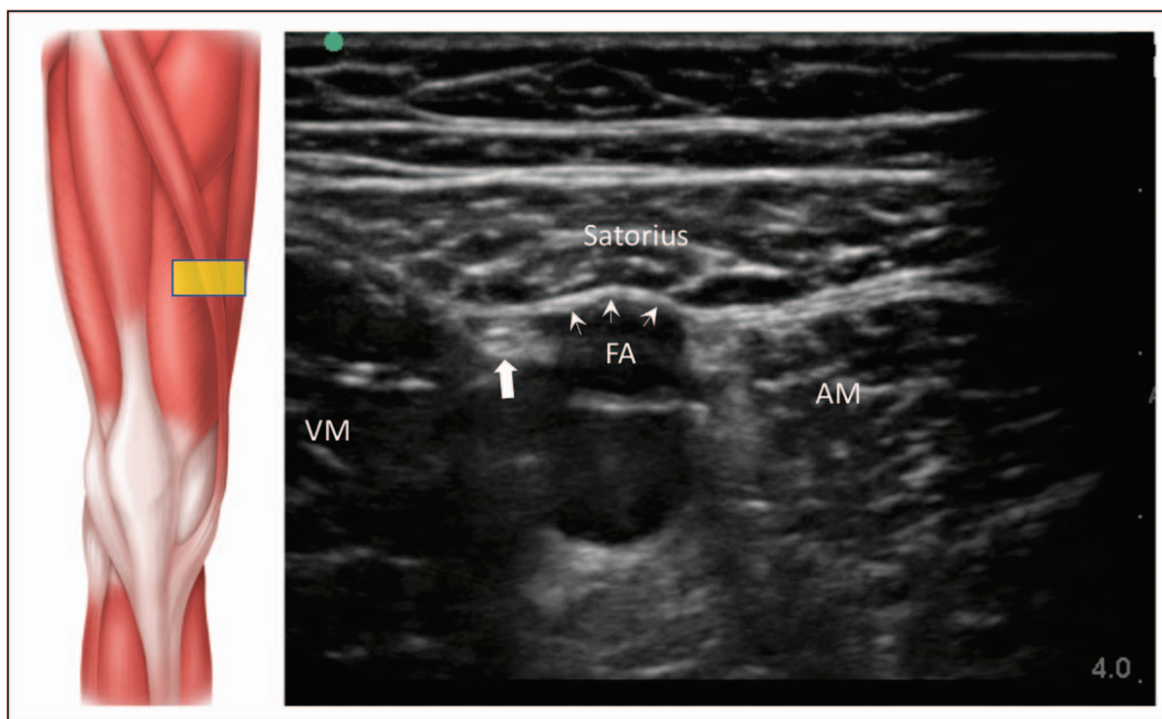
Left figure shows the position of the ultrasound probe (yellow) over the proximal end of the adductor canal. The right figure is the corresponding ultrasound image. VM: vastus medialis muscle, AM: adductor muscle, arrows: vastoadductor membrane, FA: femoral artery, Bold arrow: saphenous nerve. Reprinted with permission from Philip Peng Educational Series.
